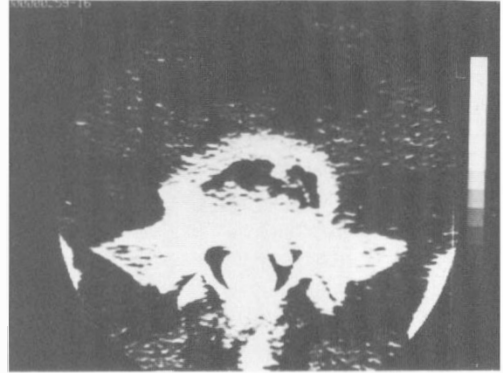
Absence of the right S1 root was noticed at the L5–S1 level on myelo-CT. S1 and S2 roots leave the dural sac at a lower level.
